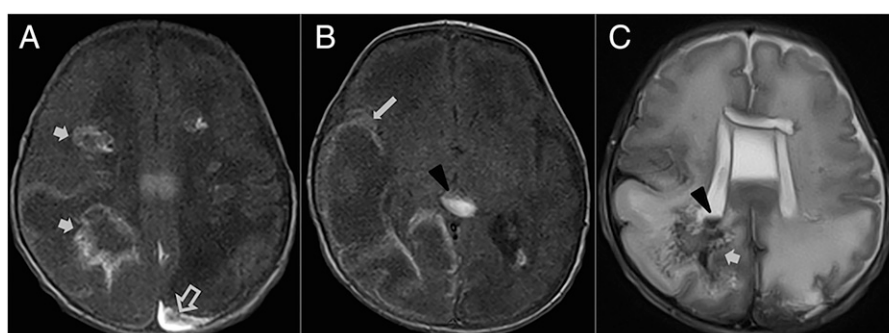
Noncontrast magnetic resonance imaging of the brain on day 18 after birth showing axial T1 (A, B) and T2 (C) sections. Multiple areas of ischemia and hemorrhage can be seen, involving brain parenchyma (thick short arrows), subdural spaces (open arrow), subarachnoid spaces (thin arrow), and intraventricular spaces (arrowheads).
